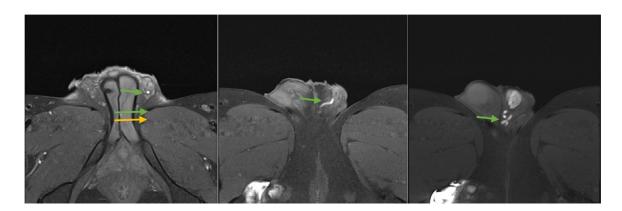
MRI T1-weighted images (axial cut) showing the dilated tortuous left ductus deferens at the spermatic cord and scrotum (green arrow).
